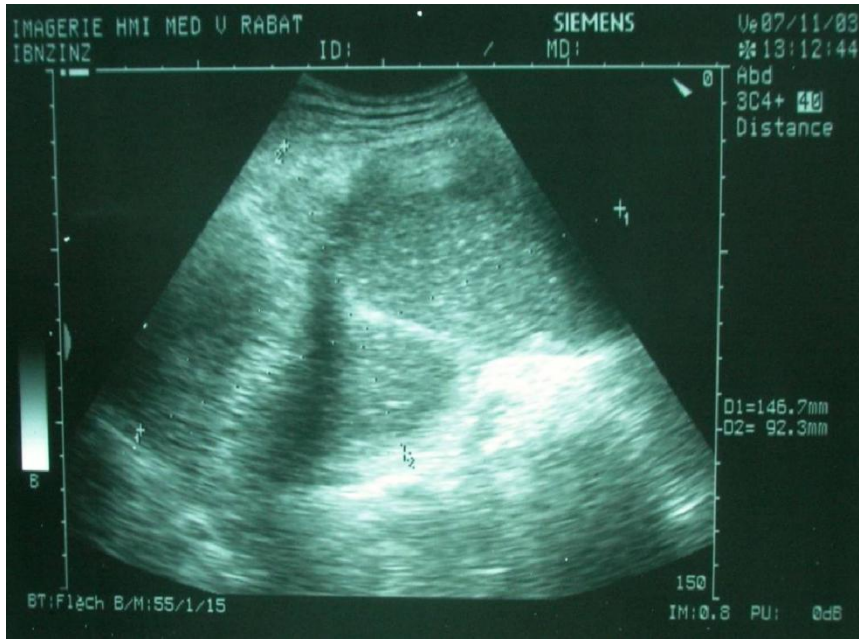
An Ultrasound Image shows a cystic mass of 15 cm corresponding to the type III hydatid cyst.
